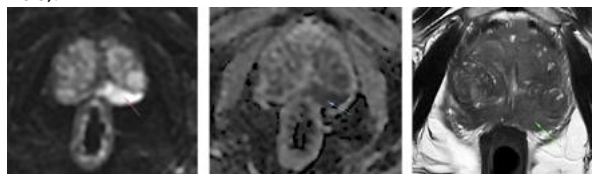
DWI (b value 2000) showing diffuse hyperintensity involving left peripheral zone; ADC images showing corresponding hypointensity; T2W image showing hypointensity instead of normal hyperintensity-these features categorizes this lesion as PIRADS 5.
